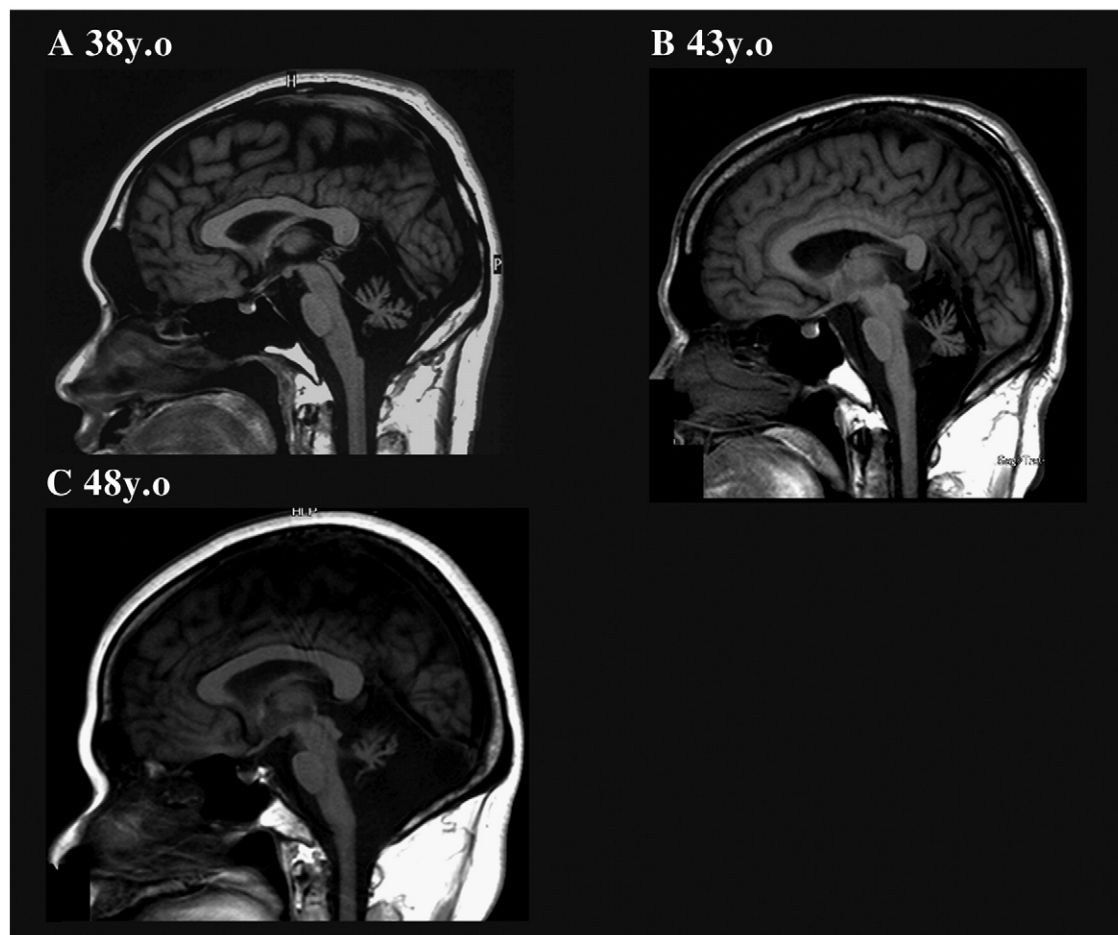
Brain MRI of 3 Japanese patients with classical MSS. Marked atrophy of the cerebellum is found in all three.
